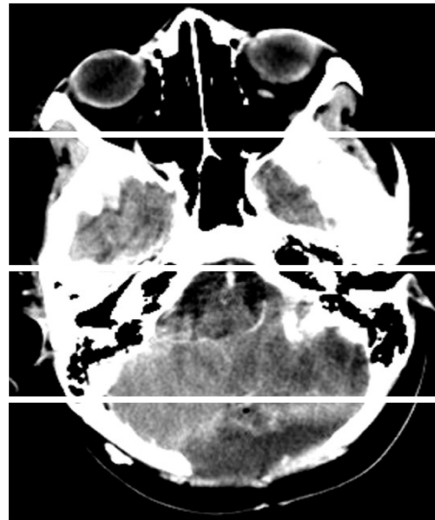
Brain CT scan in axial cut after contrast injection showing an extradural hypodensity in the FCP area at the site of the craniectomy opening, in a biconvex lens shape surrounded by peripheral contrast uptake, corresponding to an extradural empyema.
